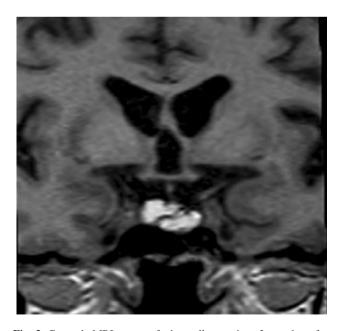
Coronal MRI scan of the sellar region 3 months after transphenoidal operation showing remnant of the cystic mass
